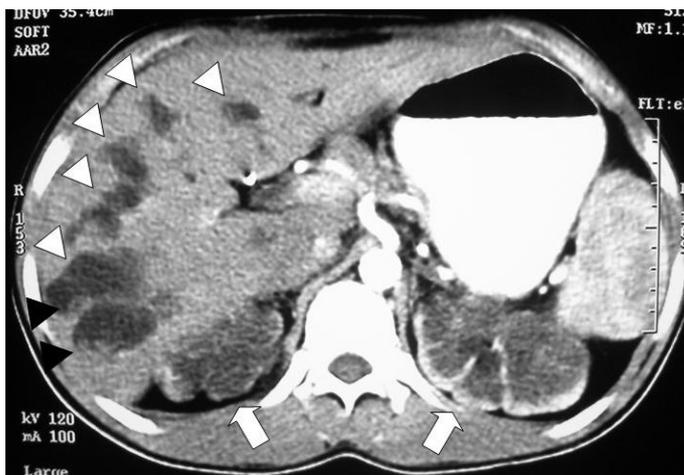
CT scan of the abdomen
